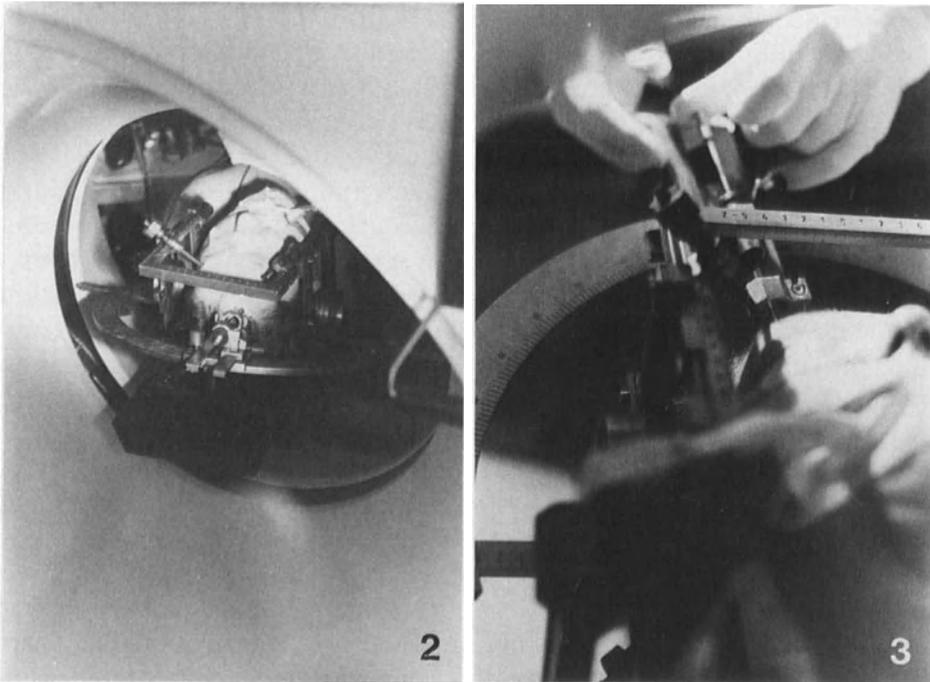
Stereotactic surgery within the CT scanner (Leksell instrument)
